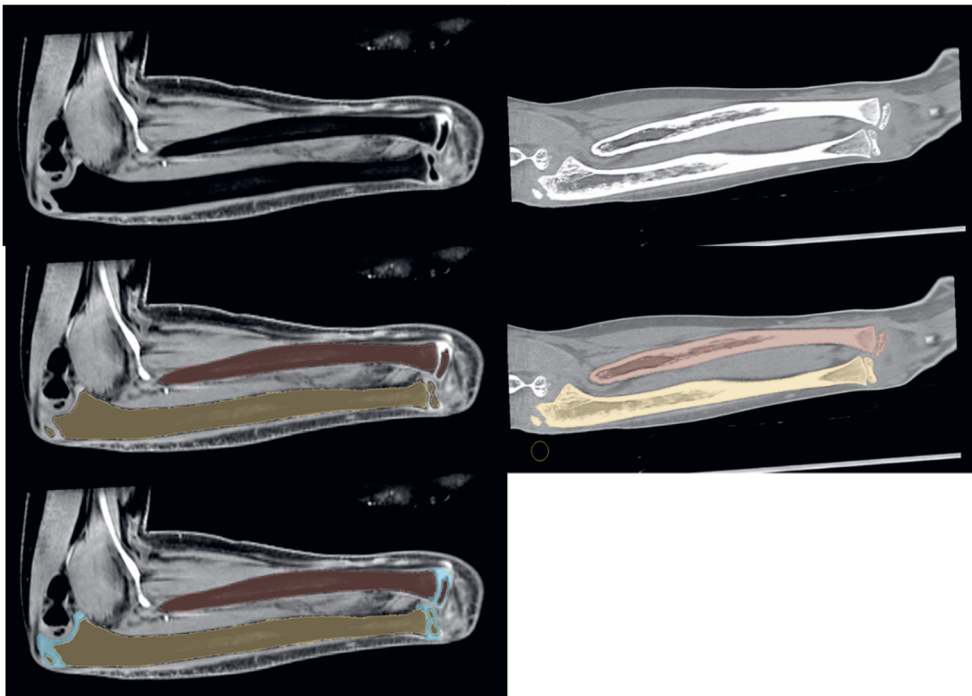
Top row: Example of the MR (left) and CT (right) images of lower right arm. Middle row: MR and CT overlaid with radius (brown) and ulna (yellow) bone segmentation. Bottom row: MR overlaid with bone and cartilage (blue) segmentation.
